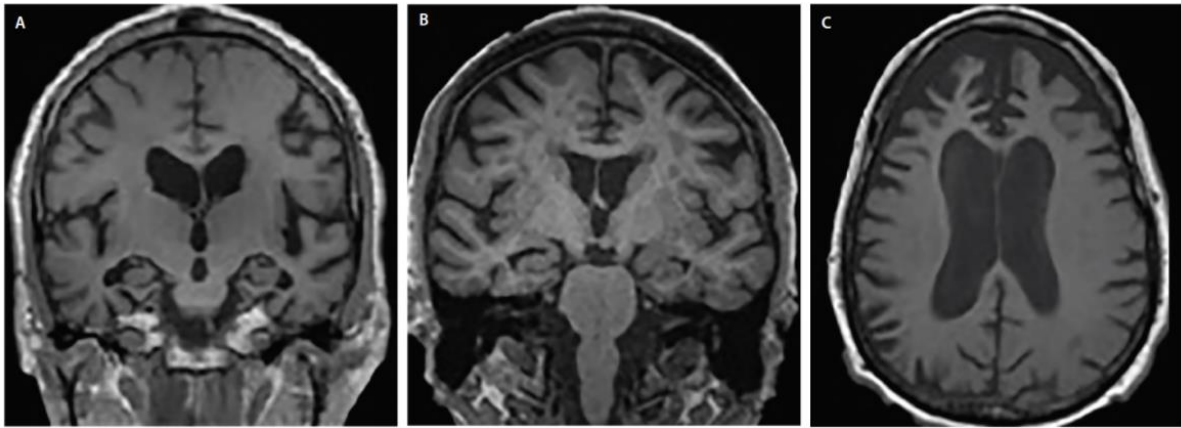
Atrophy patterns in AD (A), DLB (B) and FTLN (C). Coronal T1-weighted images show cortical deterioration in general but with greater atrophy in the hippocampus in AD (A) than in DLB (B). Axial T1-weighted image show a deterioration in the frontal and prefrontal cortices in FTLN case (C). Adapted with permission from (Ayers et al., 2019).
